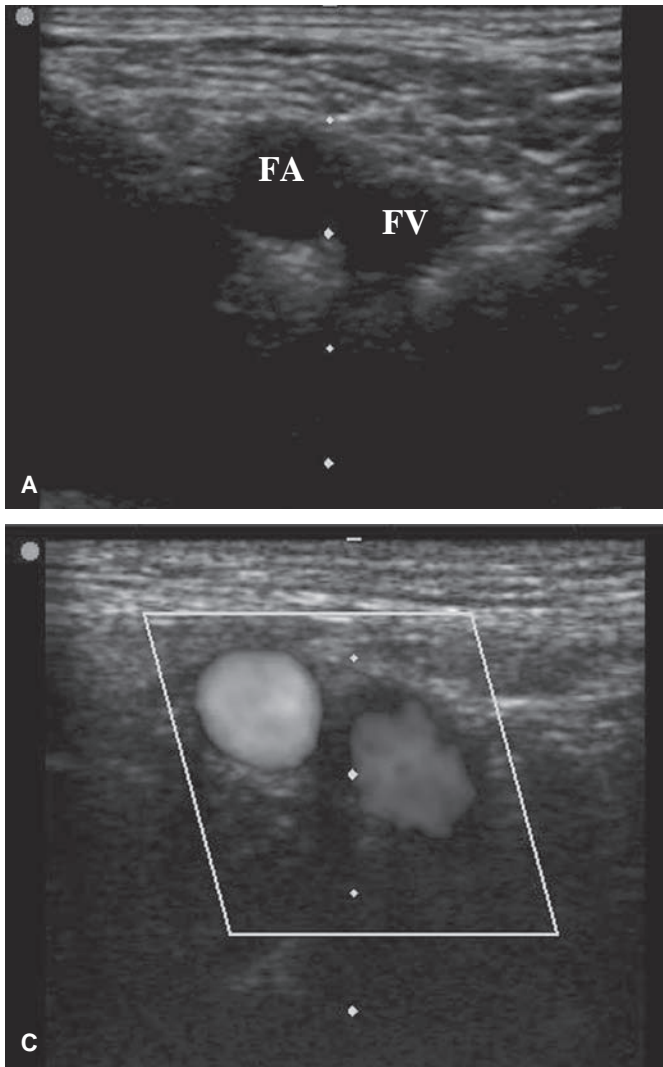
Femoral vascular anatomy. A: Femoral artery (FA) and femoral vein (FV). B: During compression, the vein collapses and is not visible, whereas the artery remains patent and visible by ultrasound. C: The femoral artery will pulsate, whereas the vein will have low constant flow or no flow depending on the sensitivity settings of the color Doppler.
